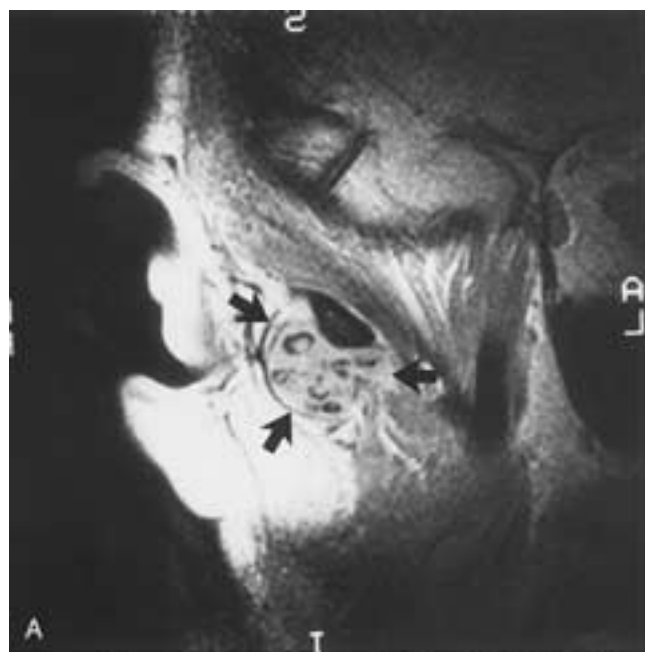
Synovial chondromatosis. A, Sagittal proton density MR image from the lateral aspect of the TMJ. There is expansion of the joint capsule (arrows), with multiple areas of low signal. B, Coronal proton density MR image. In the coronal image there is expansion of both the lateral and medial capsule walls (arrows). This indicates a neoplastic intraarticular process. The finding of multiple areas of low signal within the expanded joint capsule is consistent with synovial chondromatosis. C, Small bodies of cartilaginous material removed from a joint (another patient) with synovial chondromatosis.
